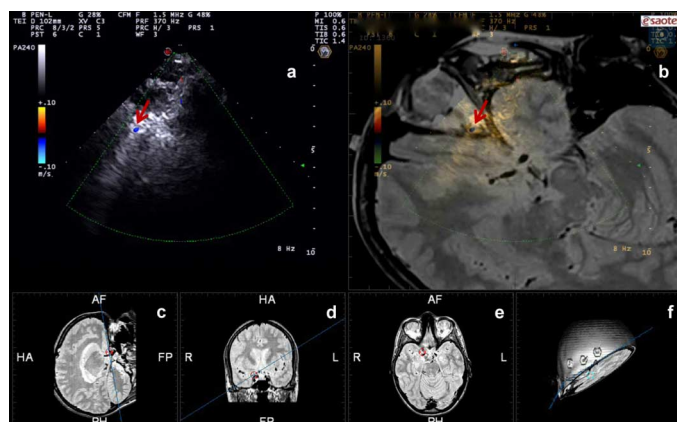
Example of ophthalmic vein (pointed by the arrow) imaged through the condylar window. (a) US image; (b) US fused with MRI. The vessel position is confirmed by the marker visualized on sagittal (c), coronal (d) and axial (e) views; (f) cut MRI rendering corresponding to the current US insonation plane.
